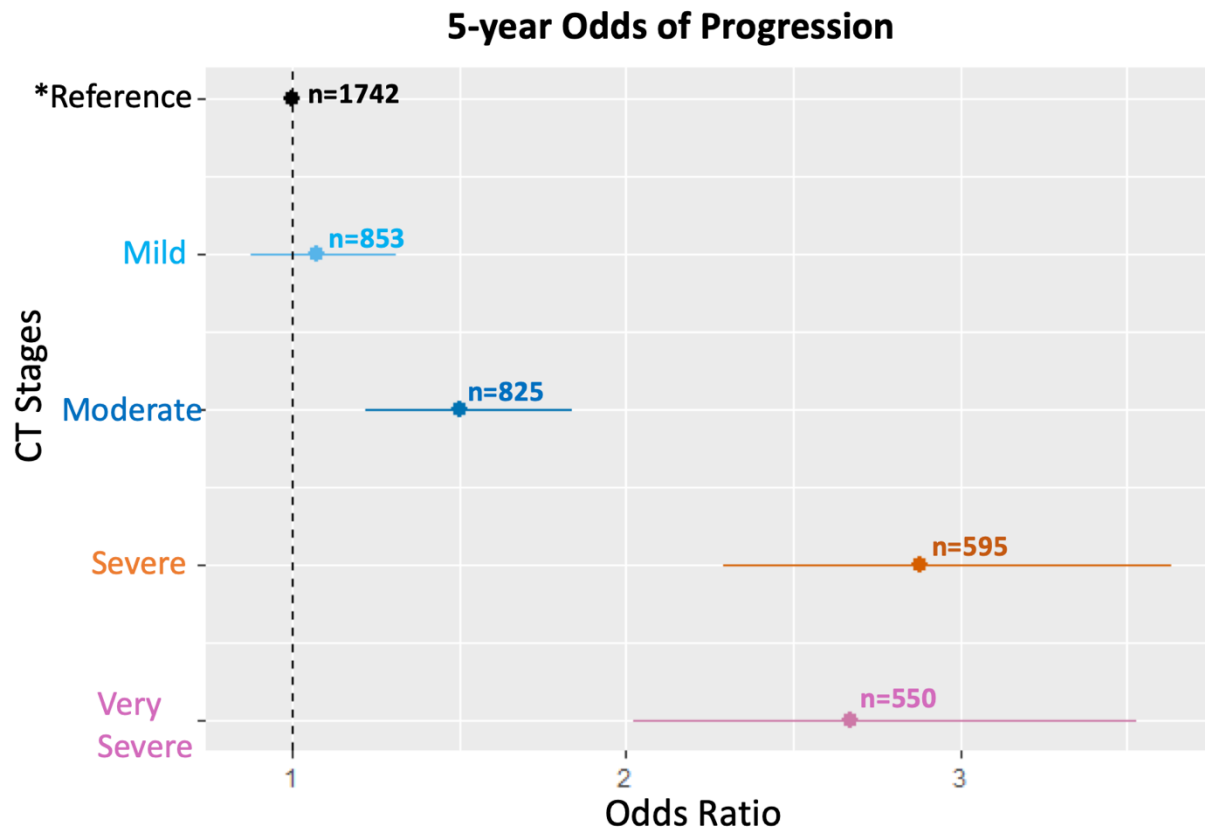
Patients with moderate to very severe disease on CT have significantly greater odds of progression in 5 years.
